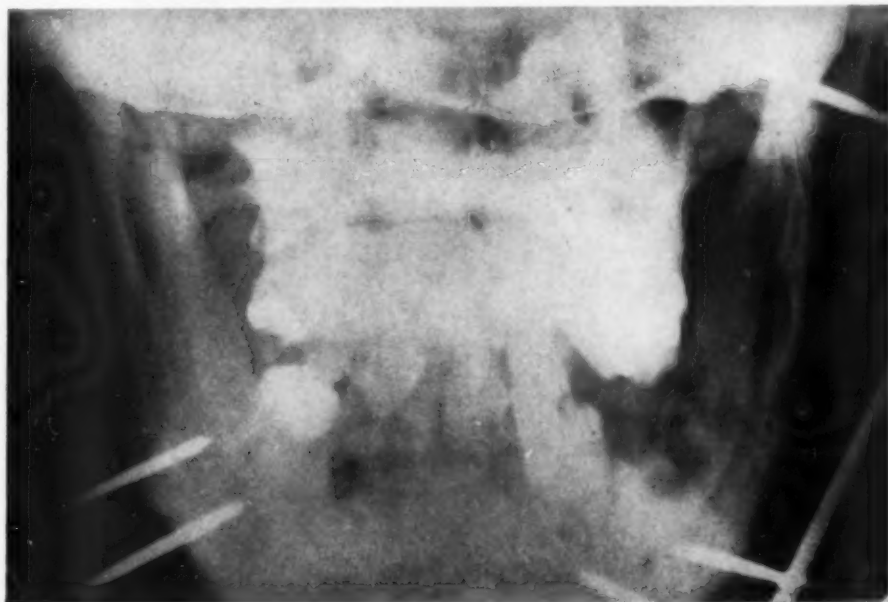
Postreduction x-ray showing condylar fracture reduced. Note four pins inserted into the mandible and the pin inserted into the zygoma.
